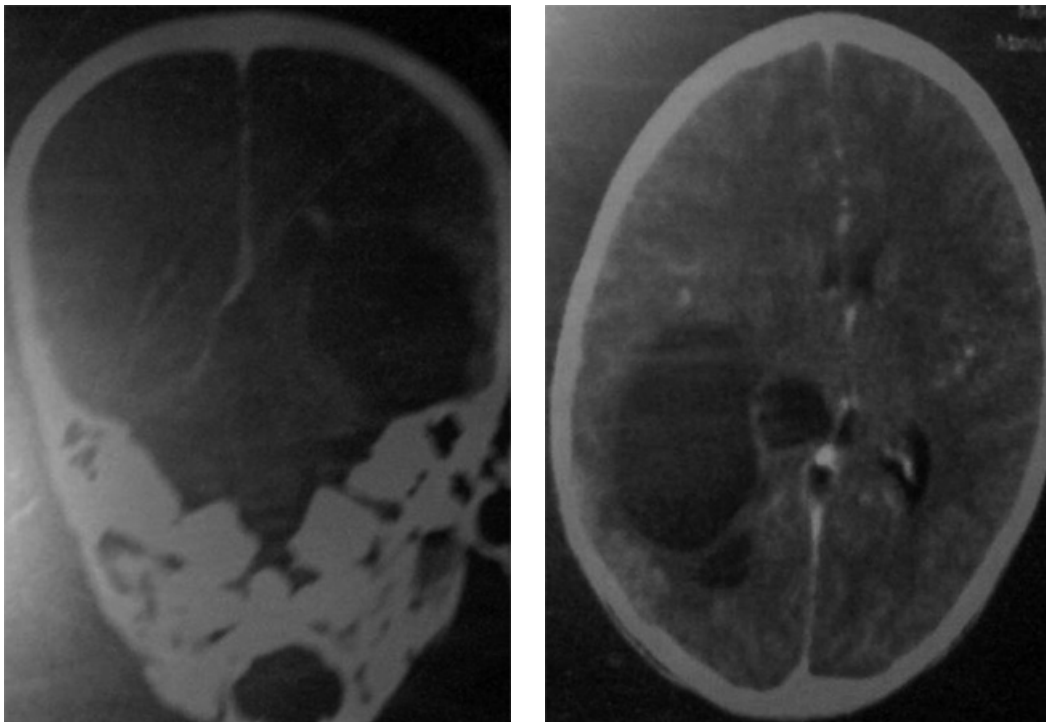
Brain CT of the patient.
